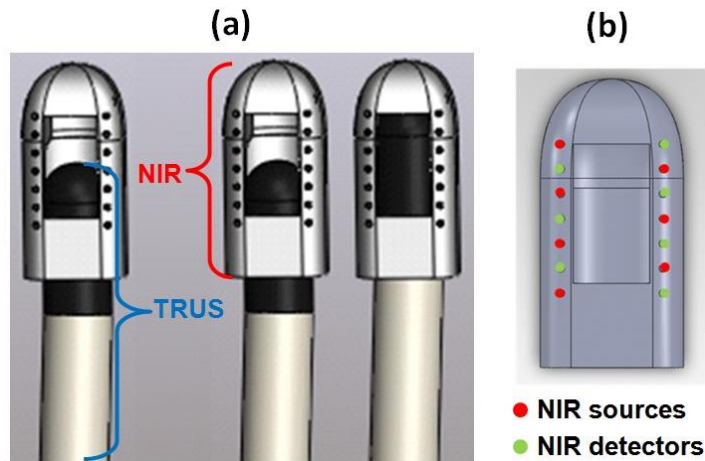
Figure C - 2 (a). The design of clip-on NIR probe to fit for BK® 8818 ultrasound transducer can fit into the probe assembly; (b) Source detector geometry of the clip-on NIR probe.
